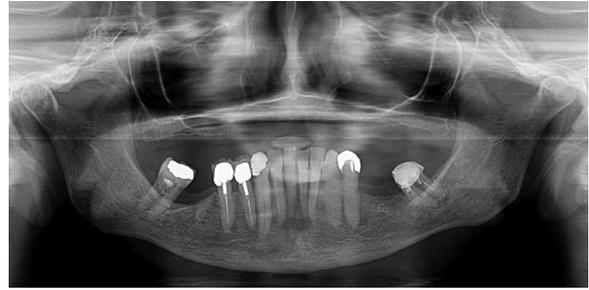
A panoramic radiograph demonstrating an edentulous maxilla.
